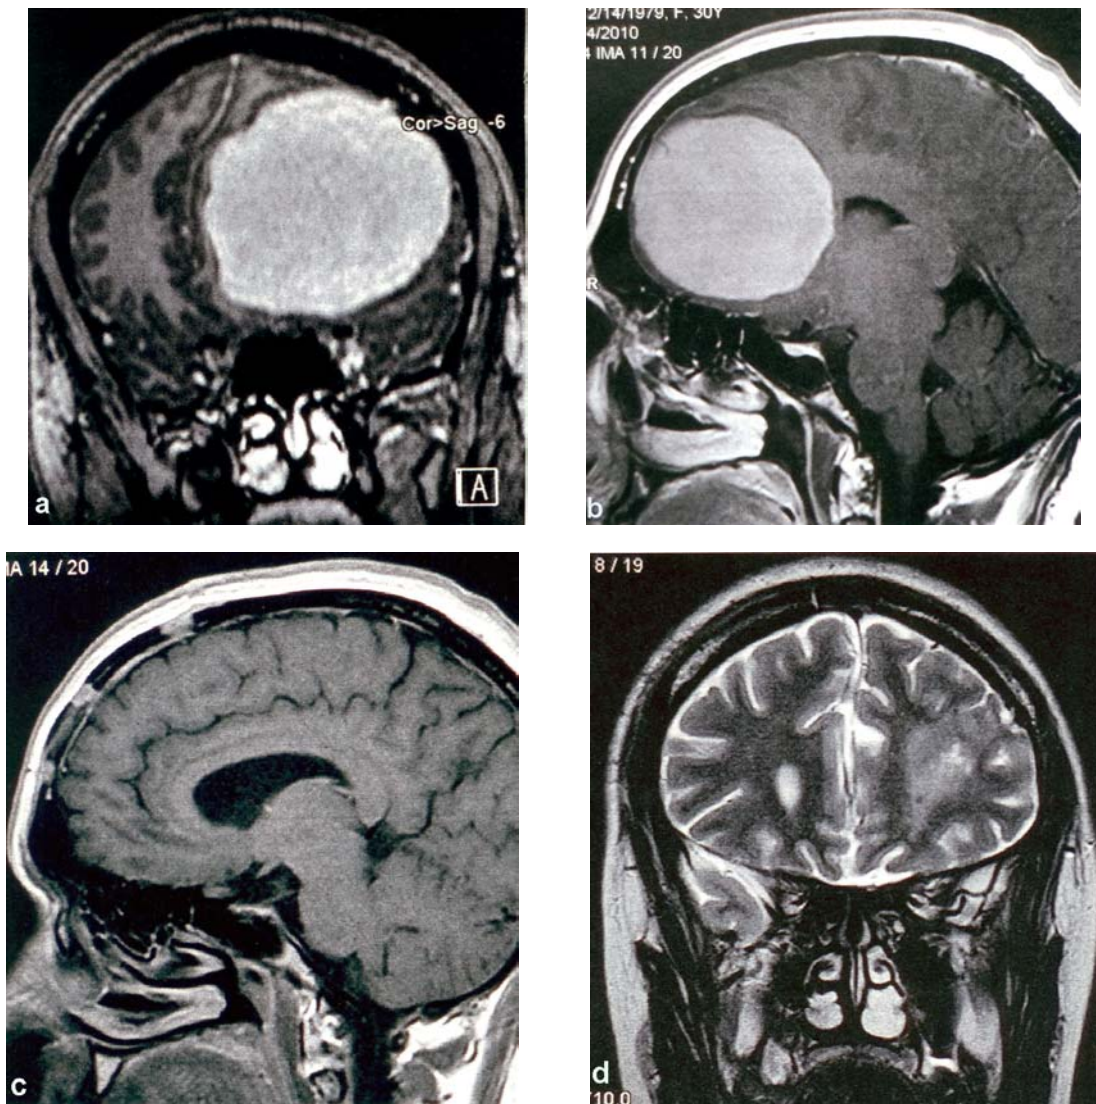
A 30-year-old woman who, besides the disorders which are specific to the dorsolateral prefrontal cortex, had also presented the degradation of the sense of pudency. The magnetic resonance imaging (MRI) examination had revealed on the anteroposterior and on the lateral images a large left prefrontal convexal meningioma (Figures 1a and 1b) which had been surgically resected in its entirety (Figures 1c and 1d) (surgeon Leon Danaila). The entire symptomatology had disappeared after the surgical treatment.
